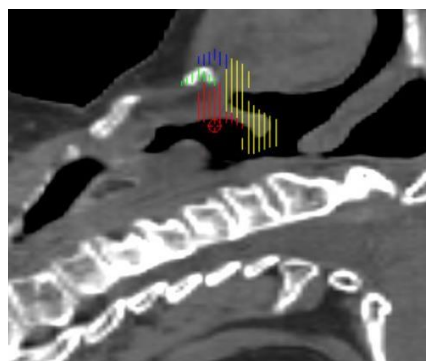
Patient A: planning CT structures added to the re-scan. The GTV and hyoid remain near each other on both scans but on the re-scan, the hyoid (green) and GTV (red) have both dropped from their original position.
